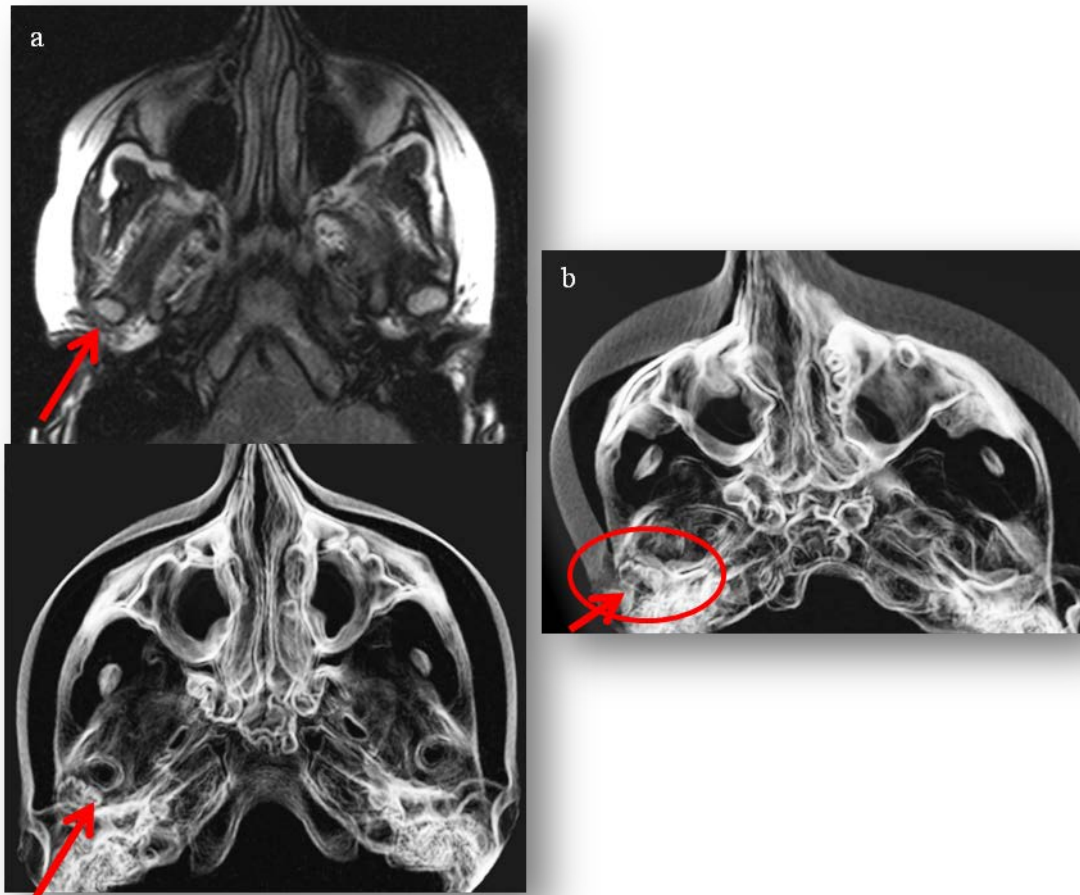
A 13-year-old girl with oligoarticular juvenile idiopathic arthritis without systemic treatment. a) Represented MRI and CBCT view. The axial view of the MRI image does not show thickening in the temporomandibular synovia of both temporomandibular joint (TMJ). Also, the MRI report from the specialist describes a normal condylar position, no presence of osteophytes and no signs of arthropathy. After applying our EPF, and after the generation of a 3D object, we can observe a shape in the lateral-distal part of the left condyle (arrowhead).b) This shape is also present in different views or planes of the 3D object when it is rotated for observation.
